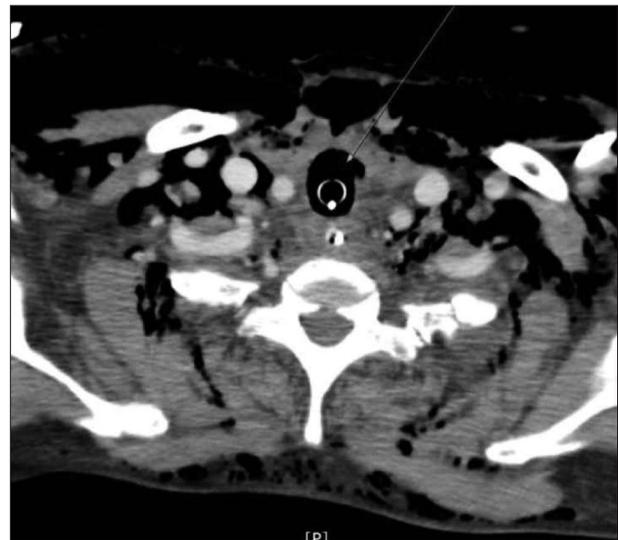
Neck computed tomography section, demonstrating extensive subcutaneous emphysema of the neck(arrow).
